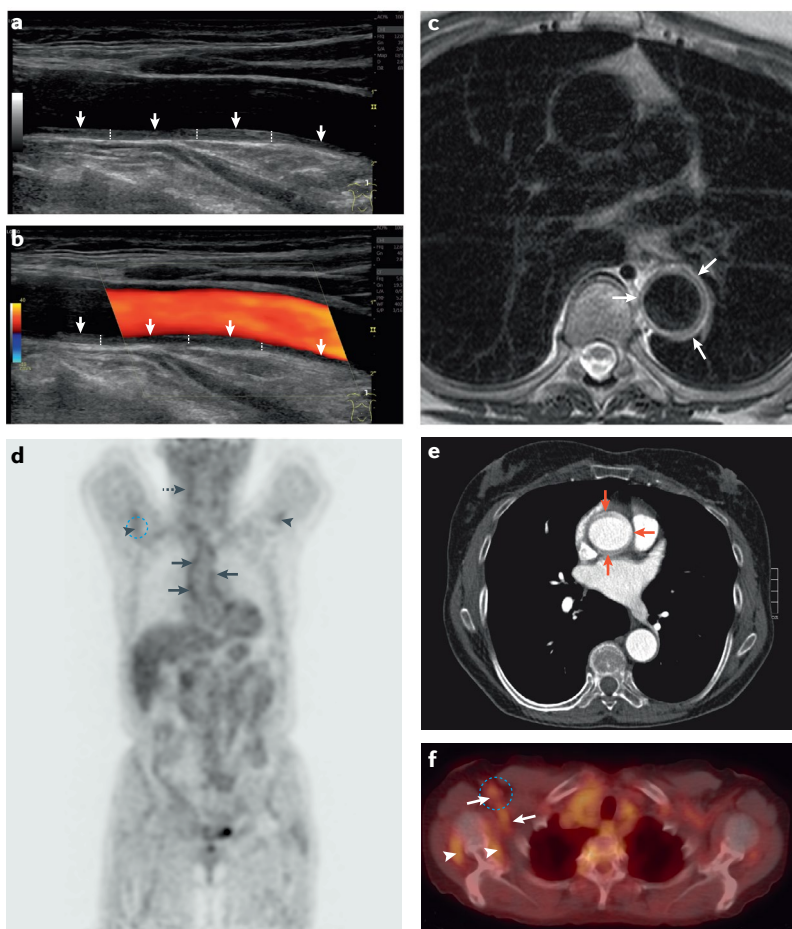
Imaging of chronic large-vessel vasculitis during glucocorticoid treatment. Different imaging techniques of the same patient, showing the appearance of chronic vasculitis during treatment. a | Ultrasonography, subclavian artery. The 'halo' sign (white arrows) with the typical homogenous and continuous wall thickening (white lines). The lamellar and hyperechoic pattern suggests chronic vasculitis. b | Same as panel a, with colour Doppler. c | MRI, axial view. Wall thickening and oedema of the descending aorta (white arrows). d | Fluorodeoxyglucose-PET, coronal reconstruction. Increased uptake of the ascending aorta (black arrows), the right carotid artery (dotted arrow) and of the axillary arteries (black arrowheads). e | Contrast-enhanced CT, axial view. Wall thickening of the ascending aorta (red arrows). f | Fluorodeoxyglucose-PET fused with CT, axial view (same scan as panel d). Increased uptake of the right axillary artery (white arrows). Capsular/peri-articular uptake of the right shoulder (white arrowheads), consistent with polymyalgia rheumatica. MRI images courtesy of M. Karner, Hospital of Brunico, Italy. PET images courtesy of M. Farsad, Hospital of Bolzano, Italy.
